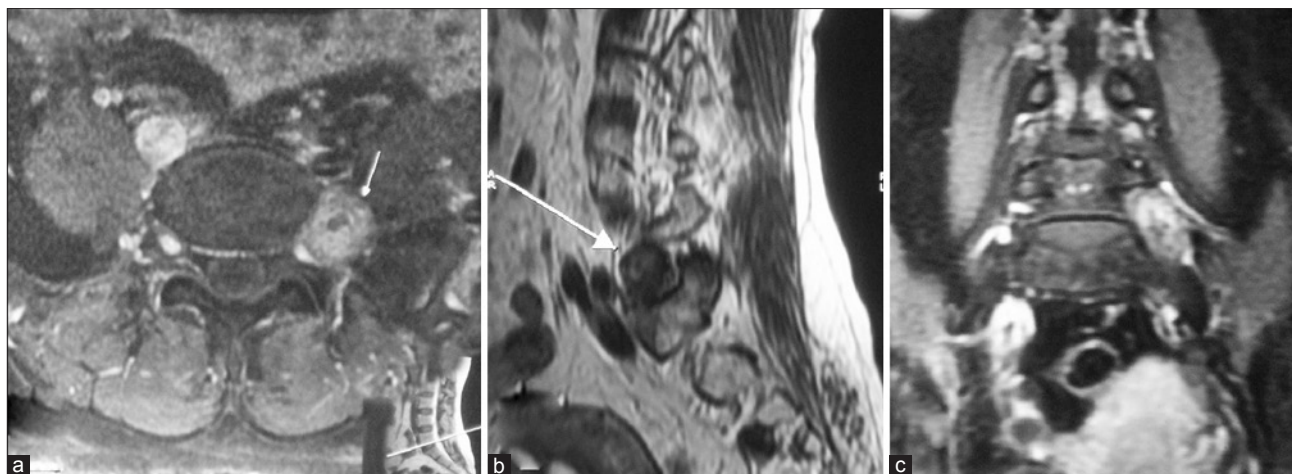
MRI lumbo-sacral (a) axial contrast image, shows an extra-spinal heterogeneously contrast enhancing globular lesion with foraminal extension and widening, (b) MRI T1WI sagittal section at the level of left neural foramen shows a hypointense lesion arising at that level, (c) MRI T1WI contrast image of coronal section at the level of neural foramen shows heterogeneously enhancing lesion arising from the left L5 nerve root
